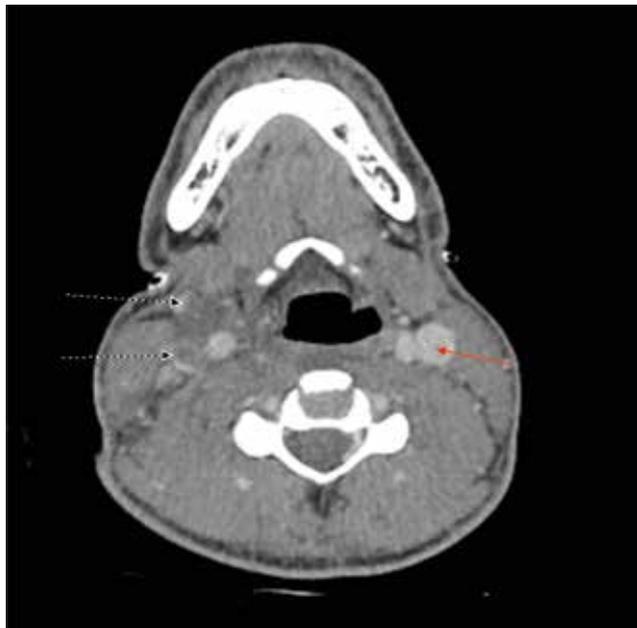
CT of the neck with a peri-tonsillar mass, and absence of contrast suggesting thrombus in the right internal jugular vein (black arrow) as compared with the normal internal jugular vein on the left (red arrow).
